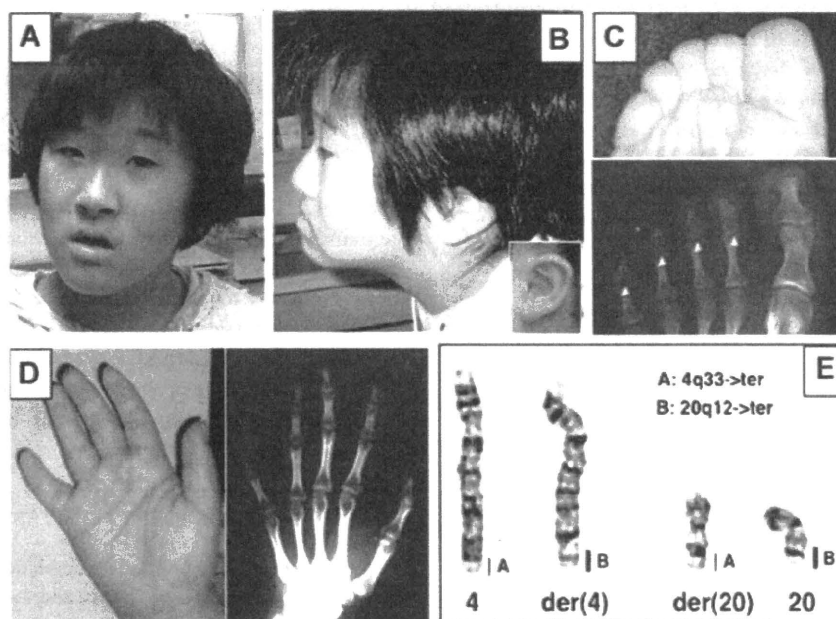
Photographs of patient 1 and G-banded chromosomes 4 and 20. A: Photograph of patient 1 at 16 years of age. Frontal face showing a milder short philtrum and shallow supraorbital ridge. B: Lateral view. C: Feet display brachydactyly with shortness of the middle phalanx of toes. D: Hands display shortness of the fifth finger but X-rays show a normal bone structure. E: High resolution G-banding of prometaphase chromosomes of the translocation derivatives and their normal homologues. A reciprocal translocation $t(4;20)(q33;q12)$ was identified.
